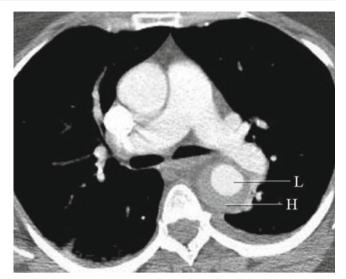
Intramural hematoma of the aorta. A contrast-enhanced CT scan of the chest demonstrates crescentic thickening of the descending thoracic aorta wall consistent with an intramural hematoma (H). Note that there is no intimal flap within the lumen (L) nor does any contrast enter the hematoma. A small left pleural effusion is also present
